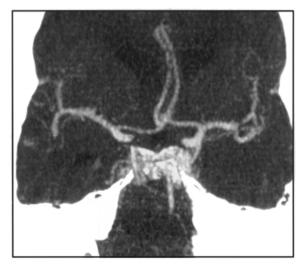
CT scan with small amount of blood in the anterior interhemispheric fissure and some sedimentation in the right occipital horn. CT angiogram of the same patient shows a small aneurysm of the anterior communicating artery.
